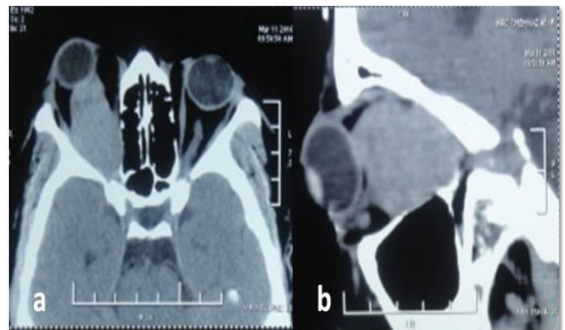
Axial(Fig. 2a) and sagittal(Fig. 2b) CT scans showing well defined isodense mass in the intraconal space of the right orbit
